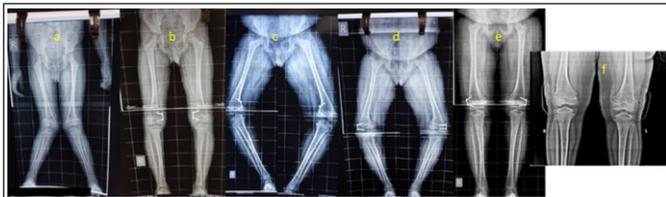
Radiograph of a child presented with bilateral genu valgum as initial deformity (a), underwent growth modulation of distal femur at 6 years of age (b), presented with overcorrected genu varum deformity (c), underwent repeat growth modulation (d), achieved deformity correction after 20 months of second surgery (e), radiograph of both knees following implant removal (f).
